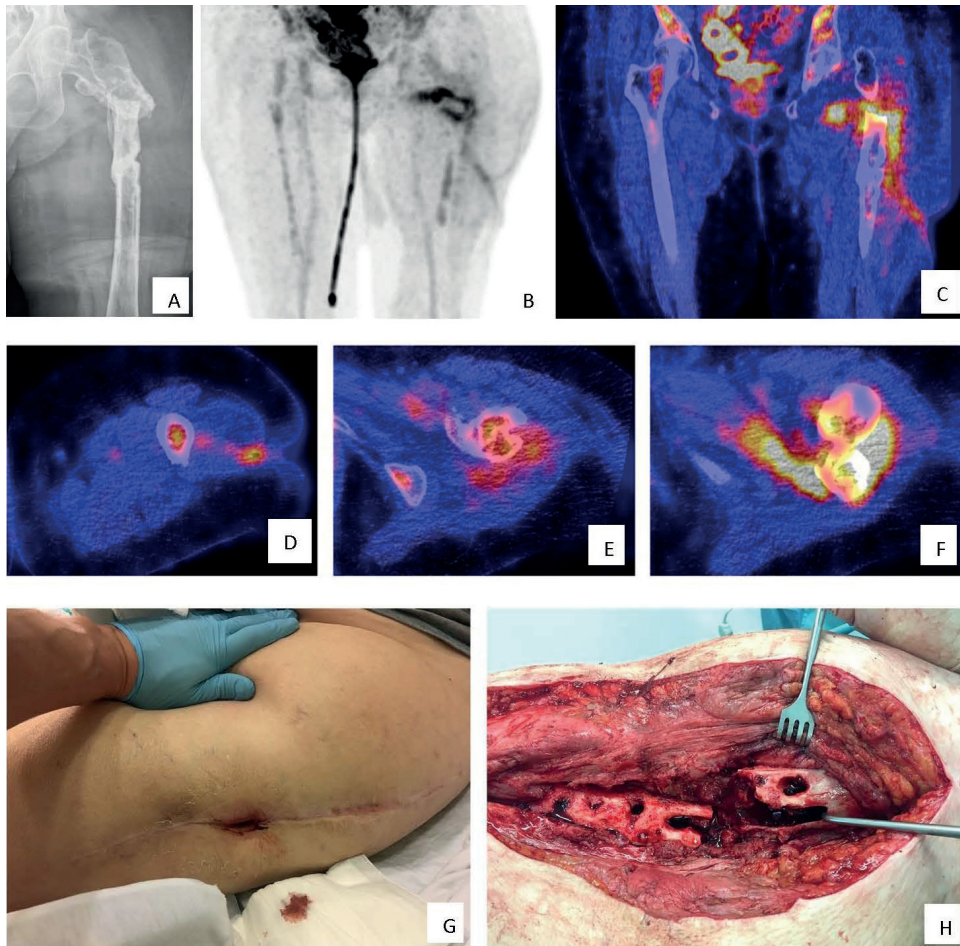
Clinical example FDG-PET/CT. A 77 year old woman who had a proximal femur fracture for which she underwent open reduction and internal fixation with a femur plate which had to be removed at a later stage due to infection. A X-ray, AP view: no consolidation, severe angulation, heterogeneous sclerotic aspect around the fracture. She was referred to our hospital with a fistula in the lateral thigh and a clinical suspicion of osteomyelitis of the proximal femur. Further imaging demonstrated an infection of the proximal femur, a medial abscess and a fistula coursing to the lateral aspect of the thigh which correlated with the clinical findings during surgery. B-F ^{18}F FDG PET/CT (B coronal FDG-PET image, C coronal fused FDG-PET/CT image, D-F transaxial fused FDG-PET/CT images). G clinical pre-operative picture H perioperative clinical picture.
